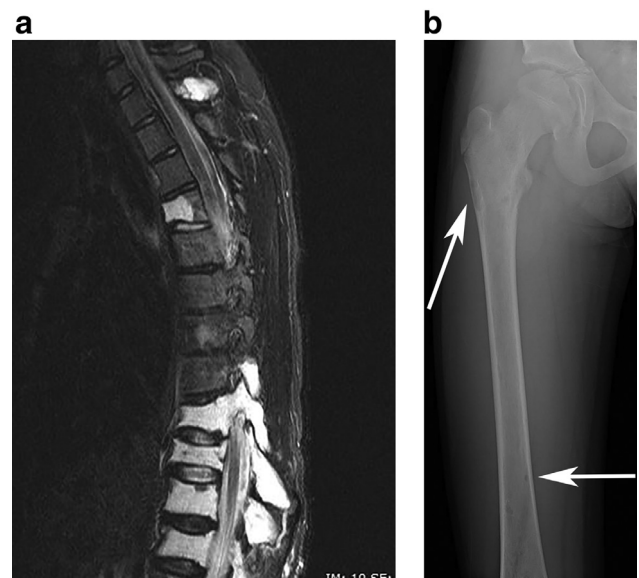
Ten-year-old girl with generalized lymphatic anomaly. (a) Sagittal STIR MRI of the spine. Multiple thoracic and lumbar vertebrae are involved, some with associated compression fractures. (b) X-ray of the right femur. Multiple discrete lytic lesions are seen in the right femur (arrows) with preservation of the surrounding cortex.
